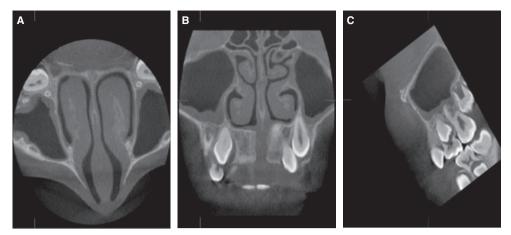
Representative cone-beam computed tomography scans of a flat mucosal thickening in an 11-year-old male patient: (A) axial scan; (B) coronal scan; and (C) sagittal scan.
